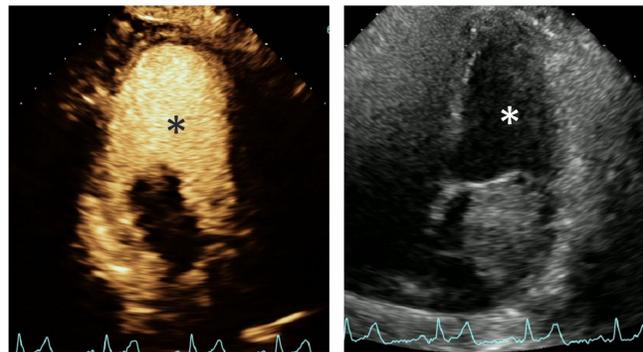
Transthoracic Echocardiogram Images
